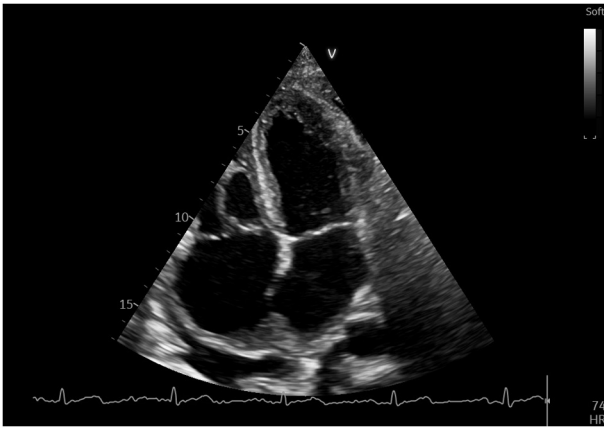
Echocardiographic apical four chamber view (5 days after chemotherapy initiation) revealing notable decrease in size of the tumoral mass is observed, which now occupies the roof of the right and left atrium and the upper portion of the interatrial septum. HR, heart rate.
